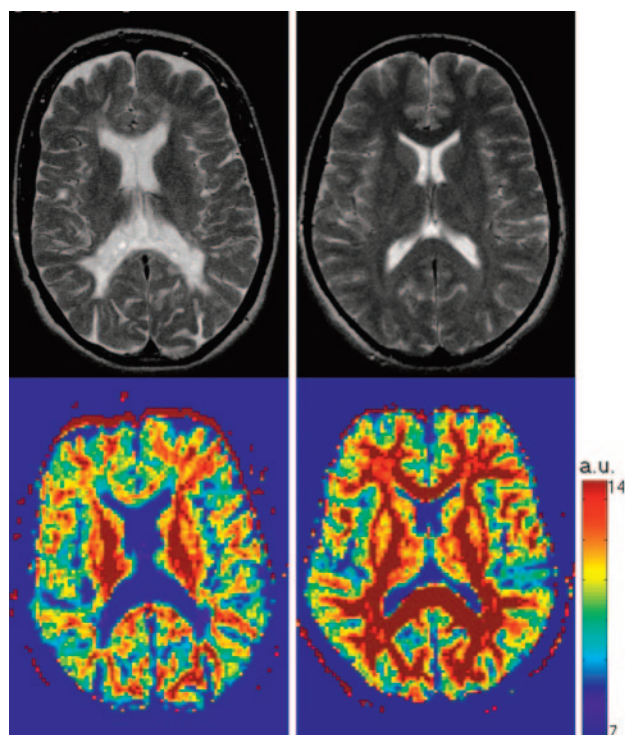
T2-weighted images (*top row*) and q-space probability for zero displacement (*bottom row*) are shown for a healthy control (*right*) and a multiple sclerosis patient (*left*). Both T2-weighted visible lesions and the normal appearing white matter are characterized by lower probability when compared with controls. a.u., arbitrary units.
